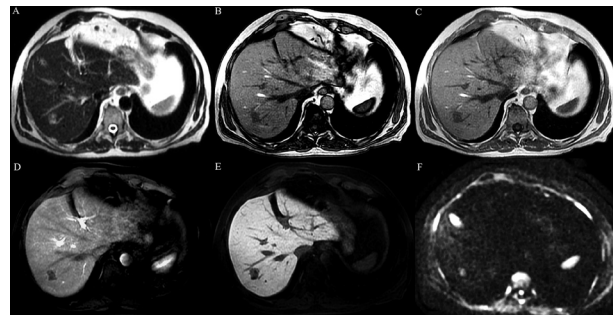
Magnetic resonance imaging shows a lesion in liver segment VII, without typical imaging findings for benign or malignant lesion on T2-weighted image (A), on opposed-phase (B) and in-phase (C) T1-weighted images, after administration of the contrast agent (D), on the hepatobiliary phase (E) and on diffusion weighted image (F).
